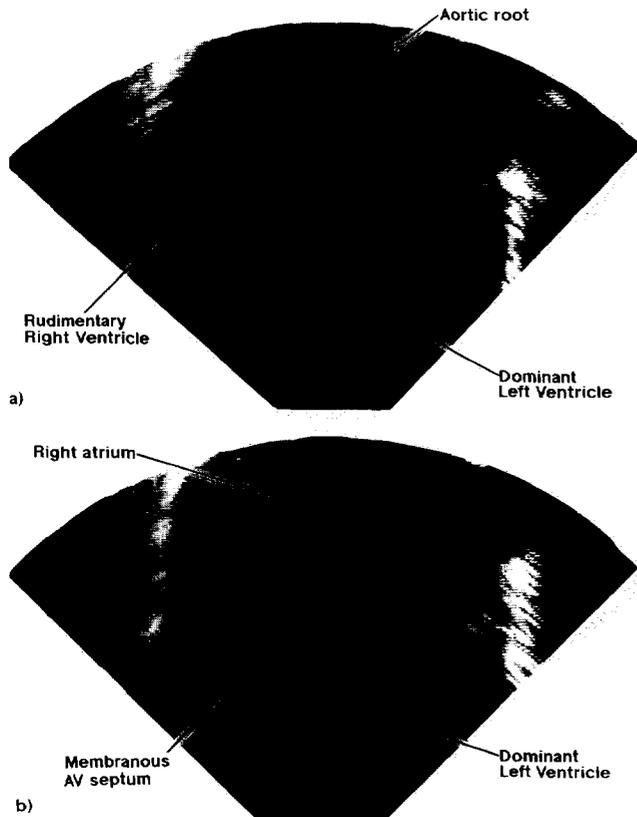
Two-dimensional echocardiograms showing the typical features of classic tricuspid atresia. The upper panel shows the aortic root interposed between the muscular floor of the right atrium and the rudimentary right ventricle. A more posterior cut, in the lower panel, shows the echo-dense wedge representing the fibrofatty tissue of the atrioventricular (AV) groove at the anticipated site of the right AV connection, which is absent. Note the location of the membranous AV septum.
